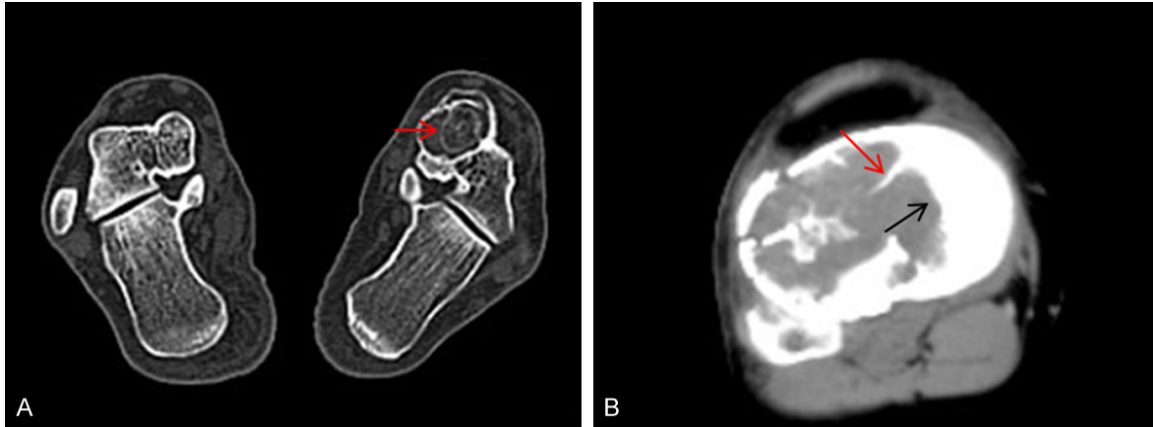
The CT of two patients diagnosed with ABC secondary to giant cell tumor showed some characteristic changes. A. Sclerotic rim; B. Wide indentations (Black arrow) and bone ridges (Red arrow).
